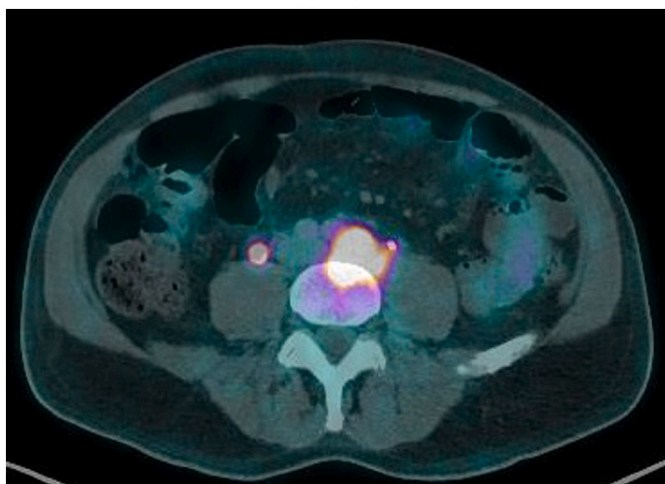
Fluorodeoxyglucose (FDG) positron emission tomography (PET) showing a pathological uptake with standardized uptake value (SUV) of 15 at the level of the paraortic lymphomatous tissue.
